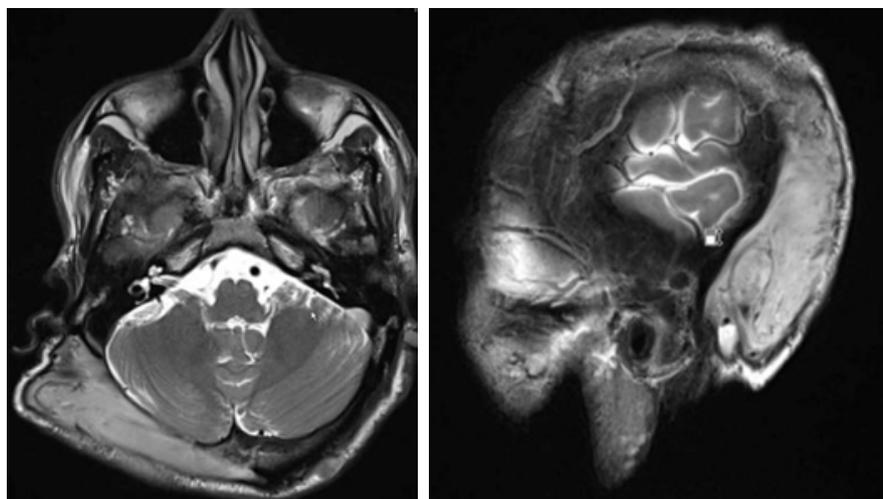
(B) MRI brain with contrast showing target sign in T2-weighted fat-suppressed images
